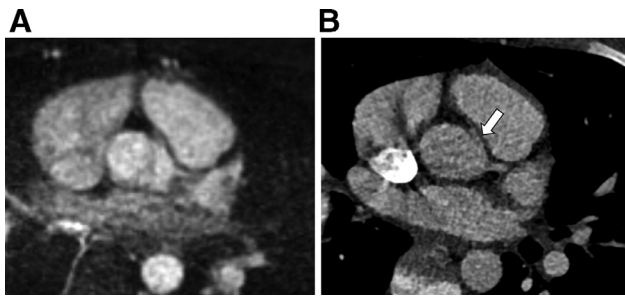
This 11-year-old boy showed an anomalous origin of the RCA from the left sinus of Valsalva with a short, proximal intramural segment using MRA (A) and CTA (B) images. The intramural segment is best visualized in CTA images (*arrow*). Furthermore, the RCA has an interarterial course between the aorta/right ventricular outflow tract and the main pulmonary artery, which is evident in both MRA and CTA images.
